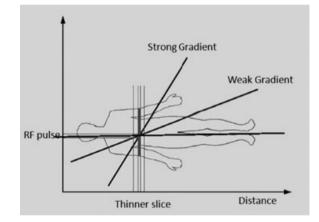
The strength of slice select gradient determines the slice thickness (figure courtesy of 'How does MRI work' by Weishaupt).
